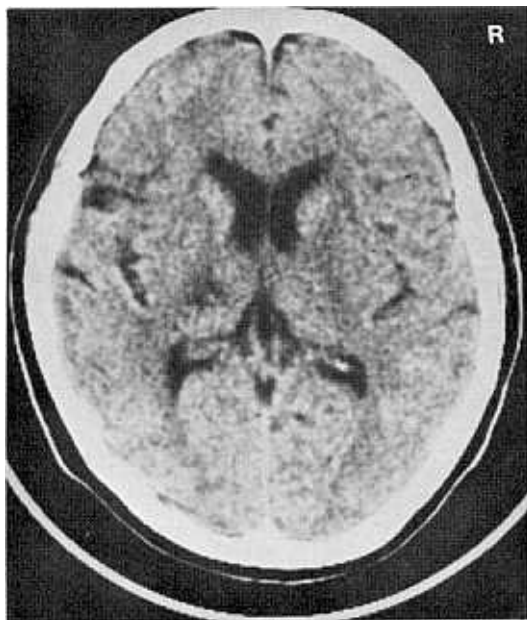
Brain CT scan of patient 3 showed focal low density in the left posterolateral thalamus.
